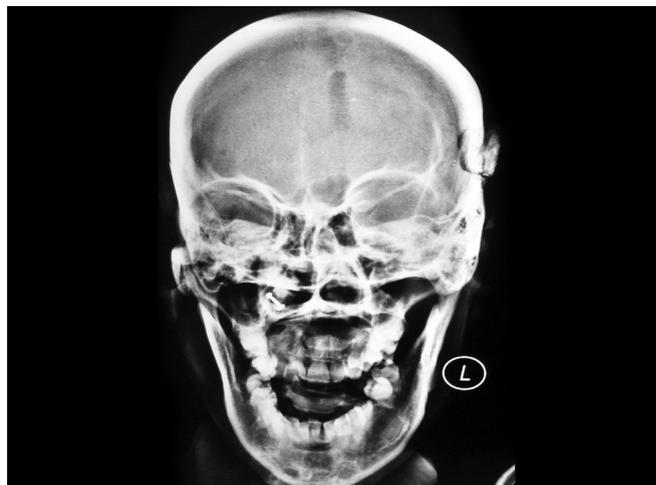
X-ray skull anteroposterior view showing elevated fracture involving left temporal and parietal bone
